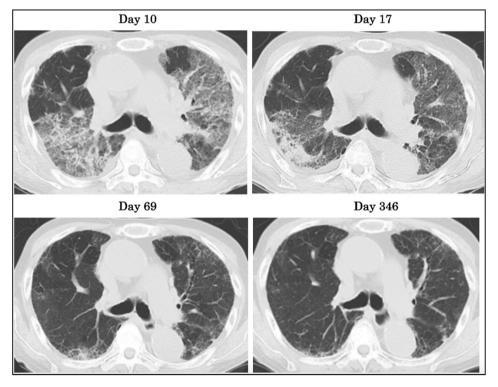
Computed tomography scans obtained during the treatment. On Day 10, the scan shows deterioration after therapeutic plasma exchange. On Day 17, after 5 days of intravenous immunoglobulin therapy, there is improvement. On Day 69, after the patient had been discharged, the interstitial shadows have almost disappeared. From Day 346, the dose of prednisolone could be tapered.
